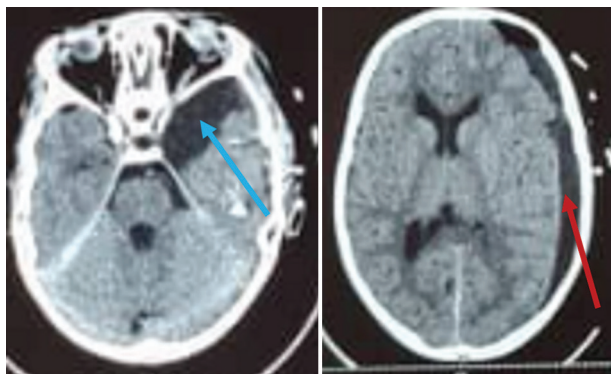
Pre-operative head computed tomography scan and magnetic resonance imaging. (A and B) Head computed tomography showing a left temporal arachnoid cyst with ipsilateral hygroma. (C and D) Head magnetic resonance imaging confirming the diagnosis. Blue arrows, left temporal arachnoid cyst; red arrows, subdural hygroma.
